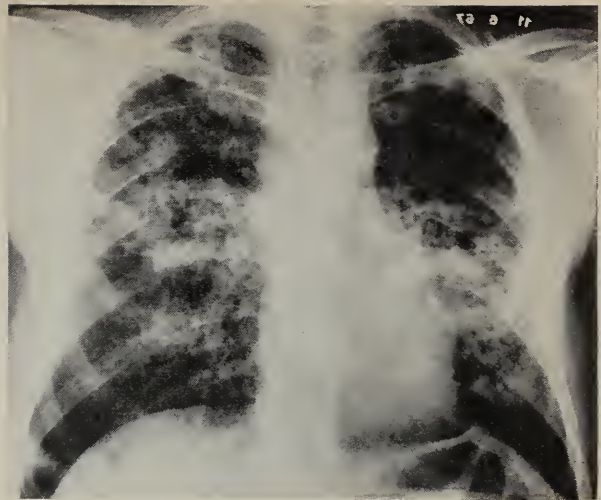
X-ray film of chest of an adult male patient with far advanced tuberculosis. Extensive infiltrations and cavities are present in both lungs.
